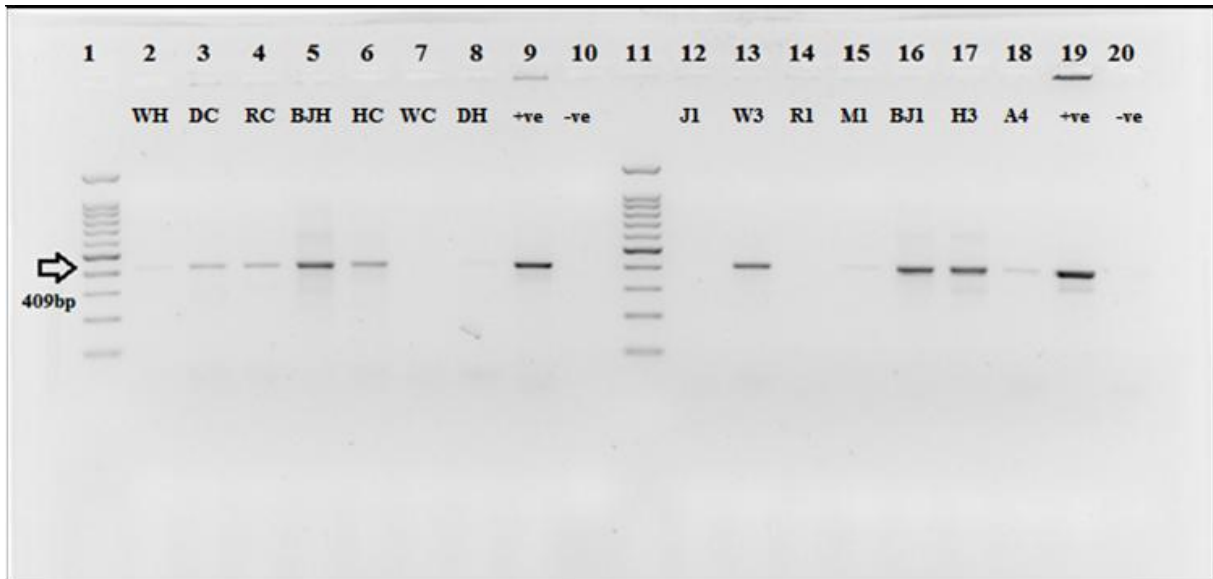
Representative 16S rRNA PCR using Com primer of DNA from hospital samples. Lane 1 represents 100bp ladder. Lane 2-8 shows sandwich filter samples (water samples), positive with 409bp and negatives results. Lane 9, positive control (*E.coli*). Lane 10, negative control (DW). Lane 11 represents 100bp ladder. Lane 12-18 show biofilm swabs samples, positive with 409bp and negatives results. Lane 19, positive control (*Legionella pneumophila* subsp.*pneu*.Philadelphia-L4-). Lane 20, negative control (DW). WH: Al-Watani hot water, DC: Rafidia cold water, RC: Ramallah cold water, BJH: Beit Jala hot water, HC: Al-Ahli cold water, WC: Al-Watani cold water, DH: Rafidia hot water, J1: Jenin operation shower hose, W3: Al-Watani pharmacy faucet, R1: Ramallah X-Ray faucet, M1: Al-Makassed labor outside faucet, BJ1: Beit Jala pediatric faucet, H3: Al-Ahli operation shower hose, and A4: Alia operation faucet 1. Complete data are shown in (Appendix E).
